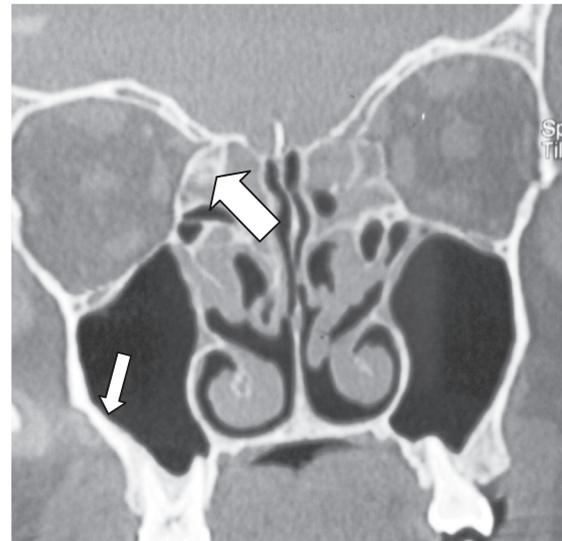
Coronal CT scan showing osteitis of the right maxillary lateral wall (arrow) and ethmoid cell walls (large arrow).
